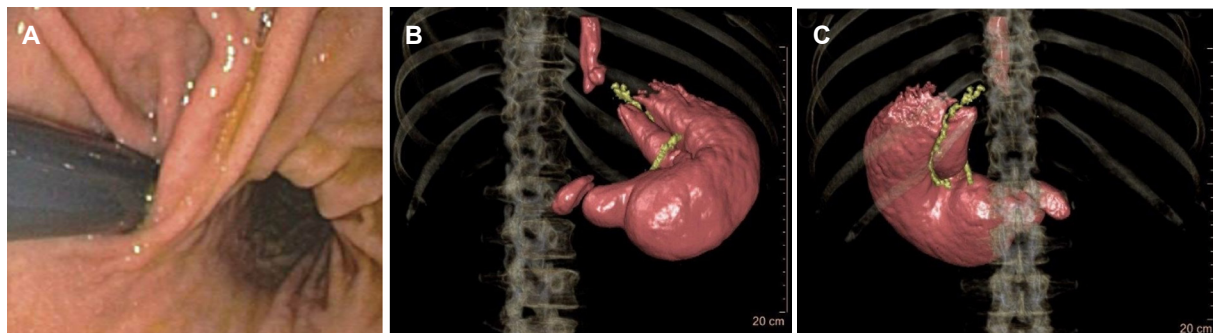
Patient after vertical banded gastroplasty. Endoscopic and 3D-CT view
